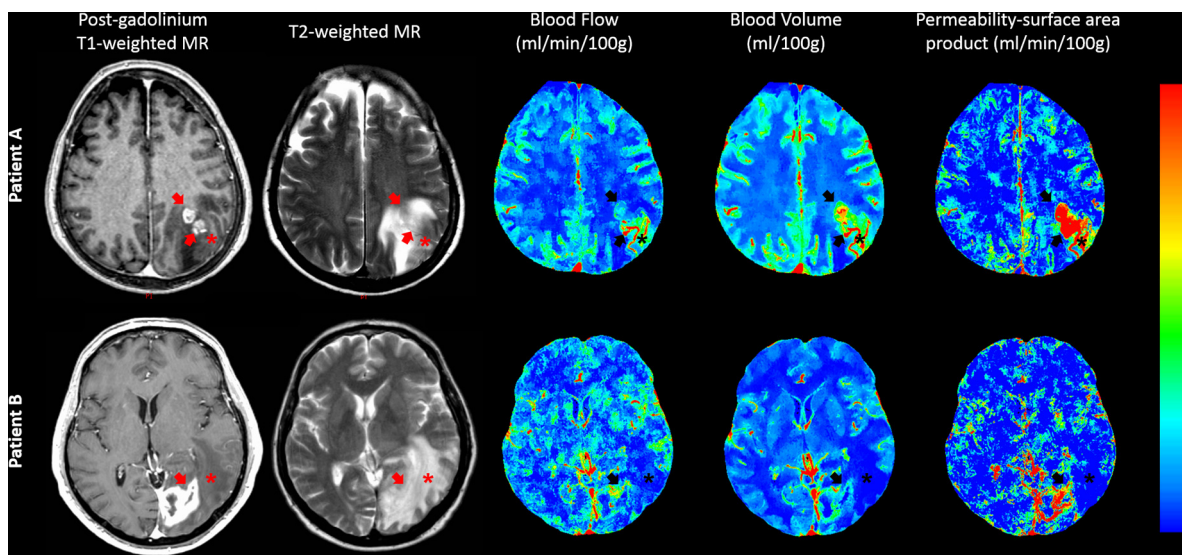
CT perfusion and MR images of patients with glioblastomas. Both patients presented with a contrast-enhancing tumor (red and black arrows) on post-gadolinium T1-weighted MR images that had high blood flow (BF), blood volume (BV), and permeability-surface area product (PS). Patient A also presented with regions of high BF, BV, and outside the contrast-enhancing tumor (red and black asterisks). Survival for Patient A was 16.7 months. Patient B presented with low BF, BV, and PS in the peritumoral region outside the contrast-enhancing tumor (red and black asterisks). Survival for patient B was 41.6 months.
